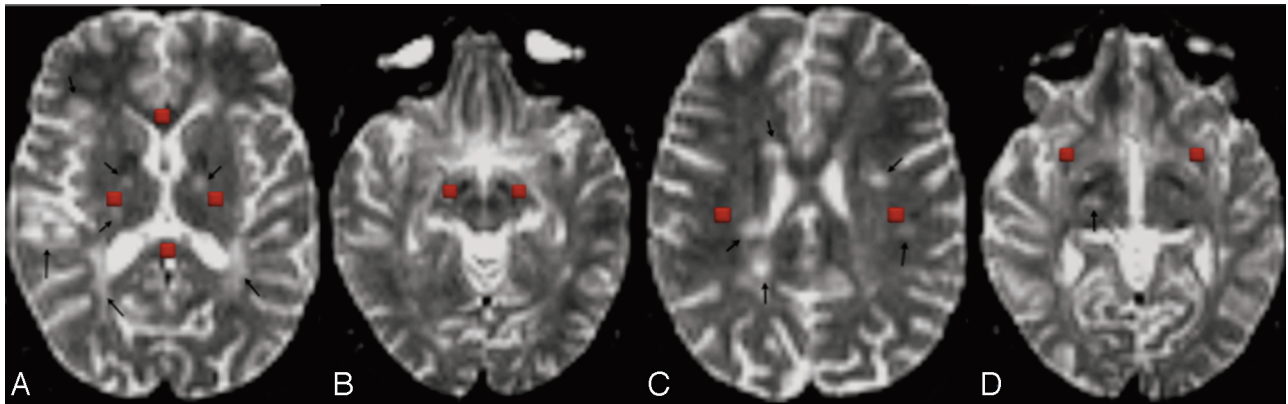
Regions of interest in the NAWM are placed on $b = 0$ T2-weighted images. *A*, One ROI is placed in the genu of the CC and one, in the splenium of the CC; and bilateral ROIs are placed in the PLIC. *B*, Bilateral ROIs are placed in the CP at the level of the midbrain. *C*, Bilateral ROIs for the SLF are placed in the axial plane, one section above the body of the CC lateral to the corona radiata. *D*, Bilateral ROIs are placed at the level of the anterior margin of the external capsule for the IFOF and UF. All the ROIs are red.
